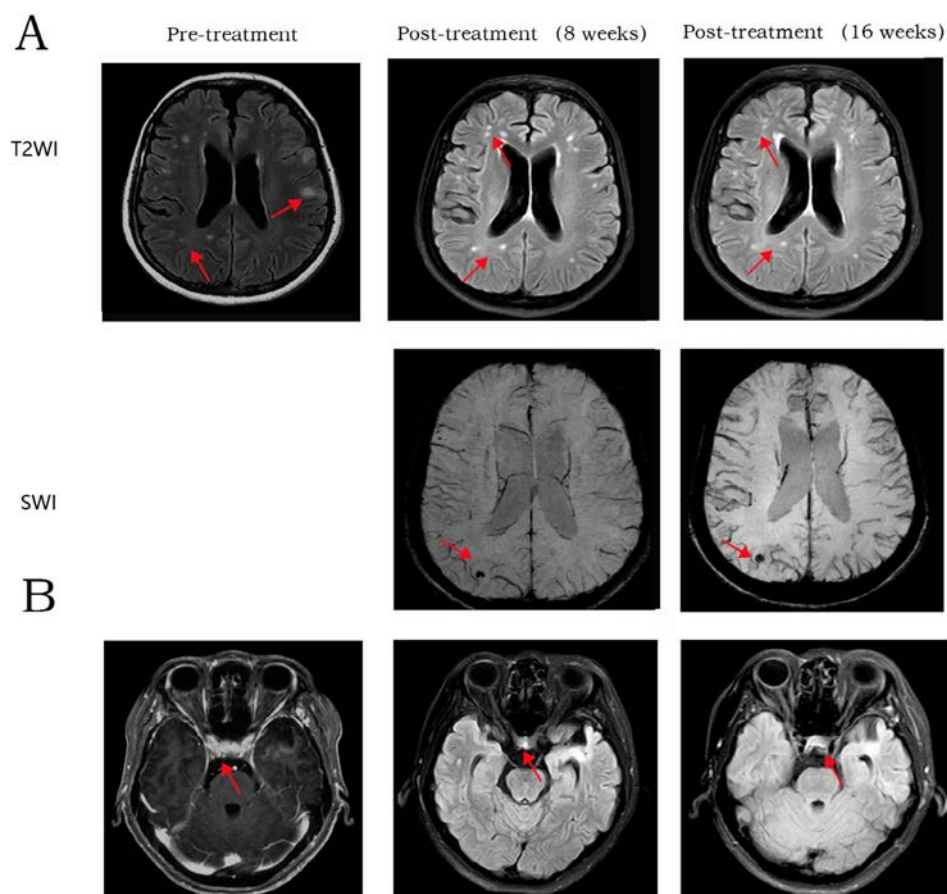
Brain MRI images of the patient. (A) On the left is the T2WI sequence, suggesting multiple demyelinating changes. On the right, the SWI sequences reveal a nodular hypointensity in the right parietal lobe, suggestive of a vascular abnormality or old microbleed. (B) Changes in optic chiasm at 8W and 16W before and after treatment.
